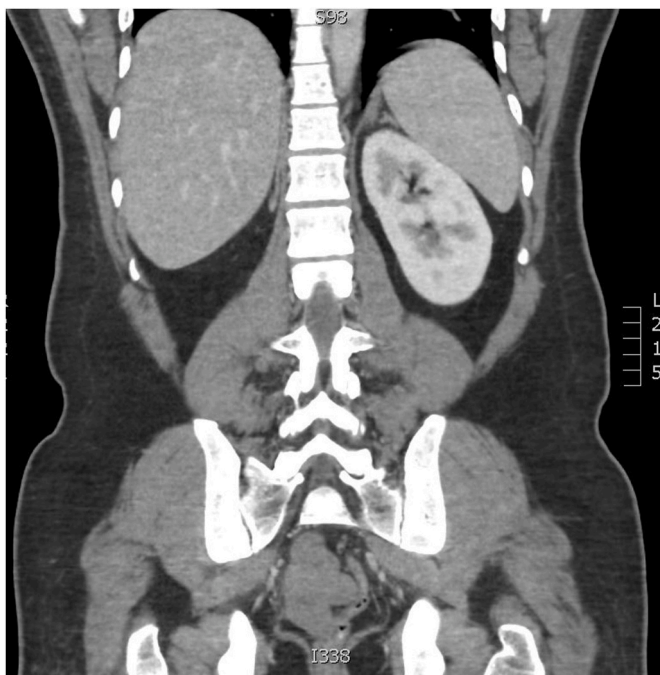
CT coronal section of the Kidney, abdomen and pelvis showing right renal agenesis.
